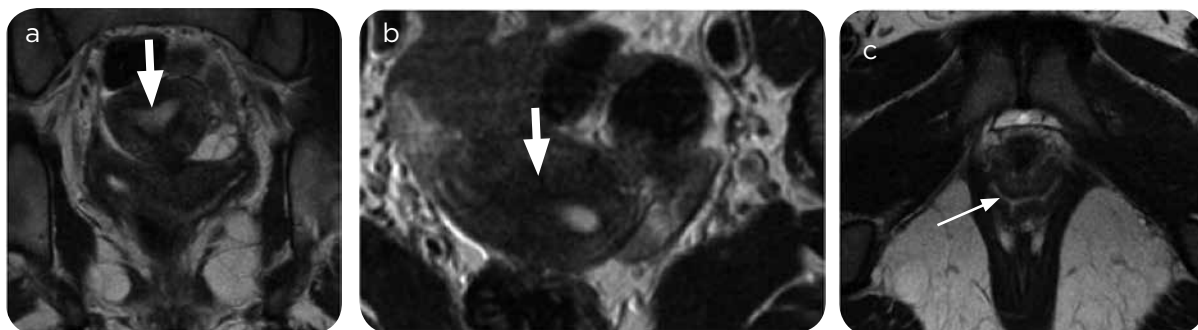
Arcuate uterus. a) TSE T2 Coronal MRI oblique to the longitudinal axis of the uterus; b and c), Axial TSE T2. Outline of the external fundus with imprint of the myometrium on the uterine cavity over the fundus (arrow in a and b). Single vagina is observed (arrow in c).
